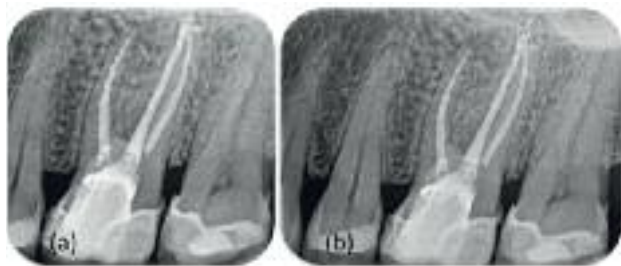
(a,b) At 12 months, the radiographic examination revealed a successful resolution of the periradicular lesion.
